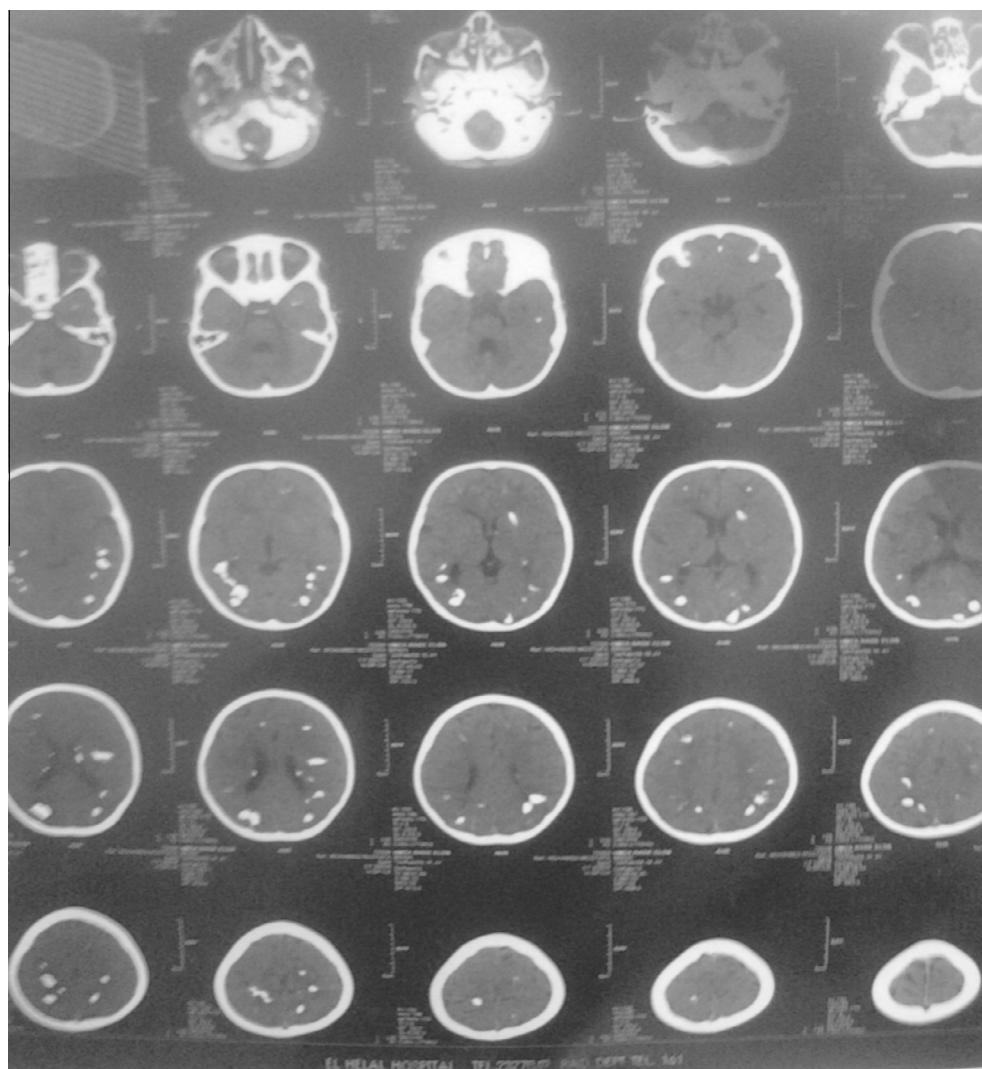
CT brain showed multiple cortical calcifications in a child with tuberous sclerosis.
